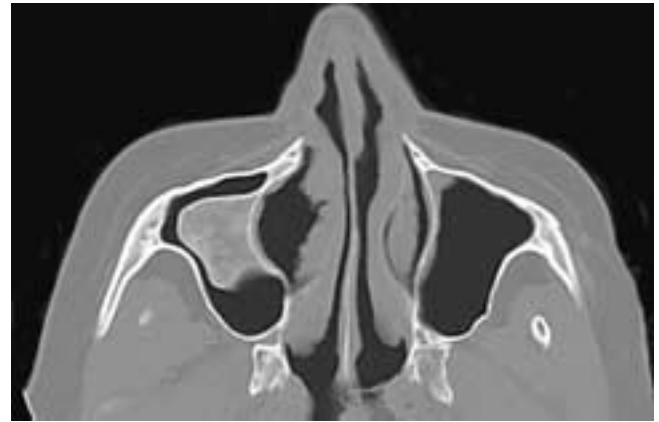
Axial CT scan shows a “ground glass” bony mass projecting into the right maxillary sinus cavity. There is a surrounding cortex. This patient had an ossifying fibroma.
